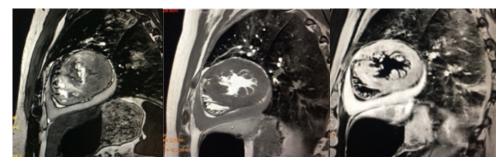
Postmortem cardiac MRI. Two-camera short-axis images. You can clearly observe the infarction of the anterior wall and left ventricular septum and the perforation of the myocardium that gave rise to the hemopericardium, allowing the determination of the cause and mechanism of death, without the need for a classic autopsy.
